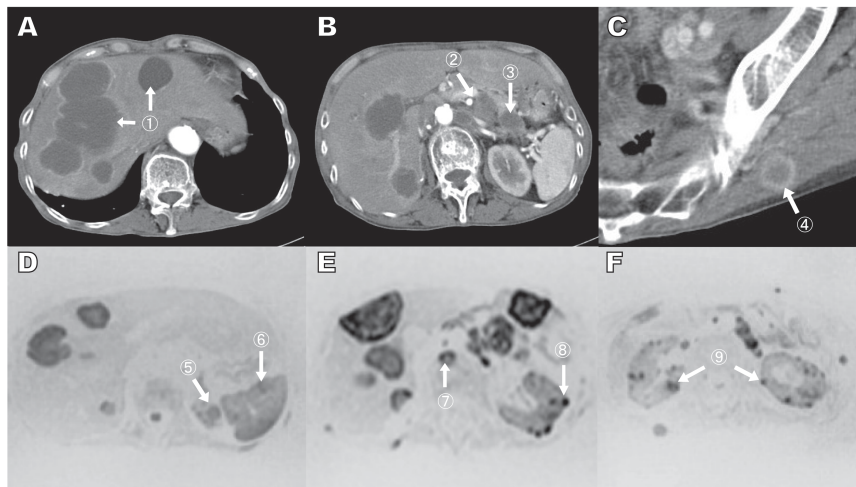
Computed tomography showing a pancreatic mass (B-3) with multiple hepatic tumors (A-1), enlarged lymph nodes (B-2), and ring-enhanced subcutaneous nodules (C-4). Magnetic resonance diffusion-weighted imaging showing high-intensity lesions in the adrenal gland (D-5), spleen (D-6), bone (D-7), and kidney (E-8, F-9).
